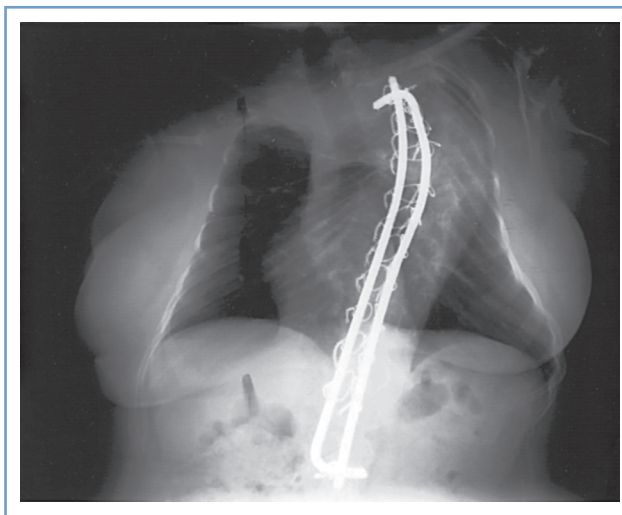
■ A chest radiograph of a 30-year-old woman with osteogenesis imperfecta type I. Generalized osteoporosis, corrected thoracic kyphoscoliosis, a restricted thoracic cage, and multiple old fractures are demonstrated. (General anesthesia was provided for cesarean delivery and tubal ligation.)
